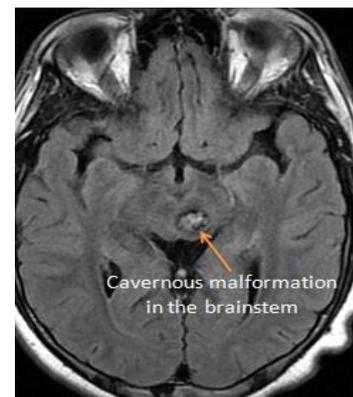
Axial MRI T1 weighted image
